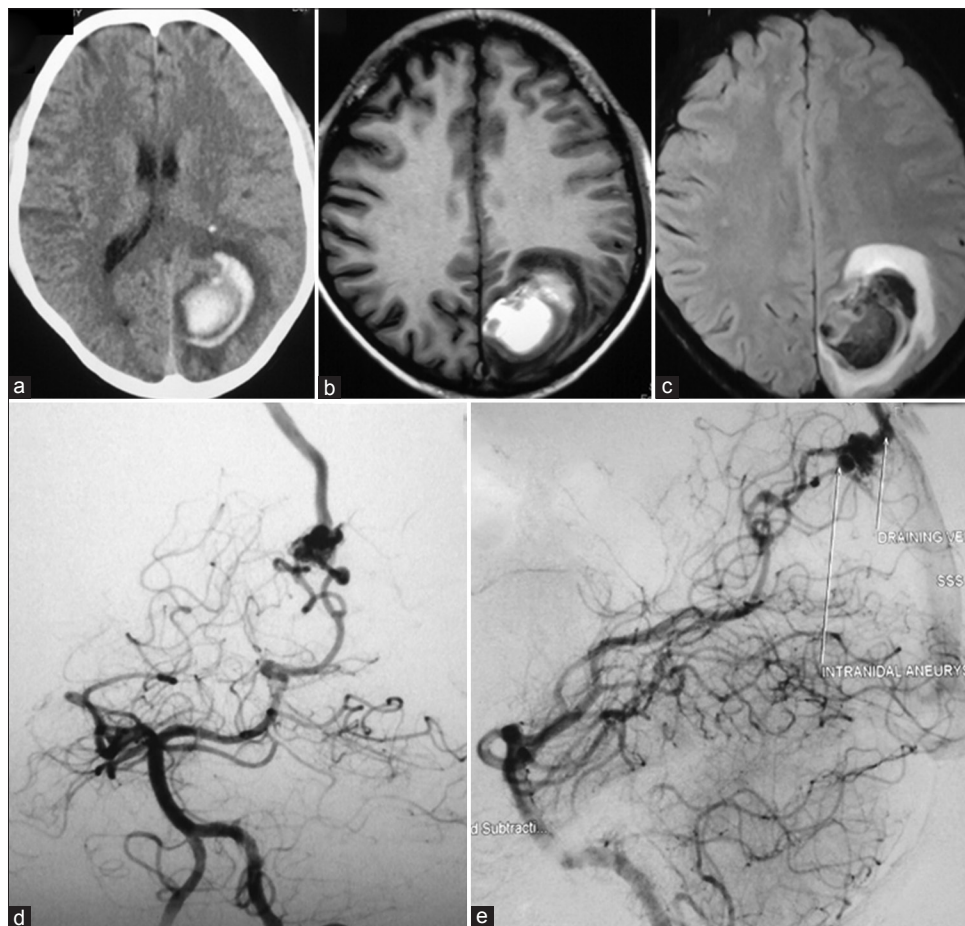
Patient 11 - (a) Axial computed tomography scan, (b and c) Axial magnetic resonance scan showing the left posterior parietal intracerebral hematoma, (d) AP view of left vertebral angiogram showing the arteriovenous malformation with intranidal aneurysm in the left parietal region, (e) Draining into superior sagittal sinus
